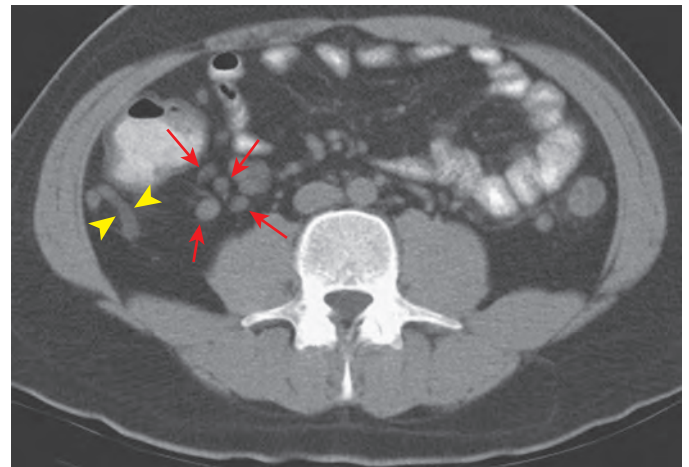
Mesenteric adenitis in a patient with Crohn's disease. Enhanced CT scan shows multiple, enlarged, right lower quadrant nodes (arrows) in this patient with Crohn's disease. The appendix was identified (arrowheads) and was normal.
